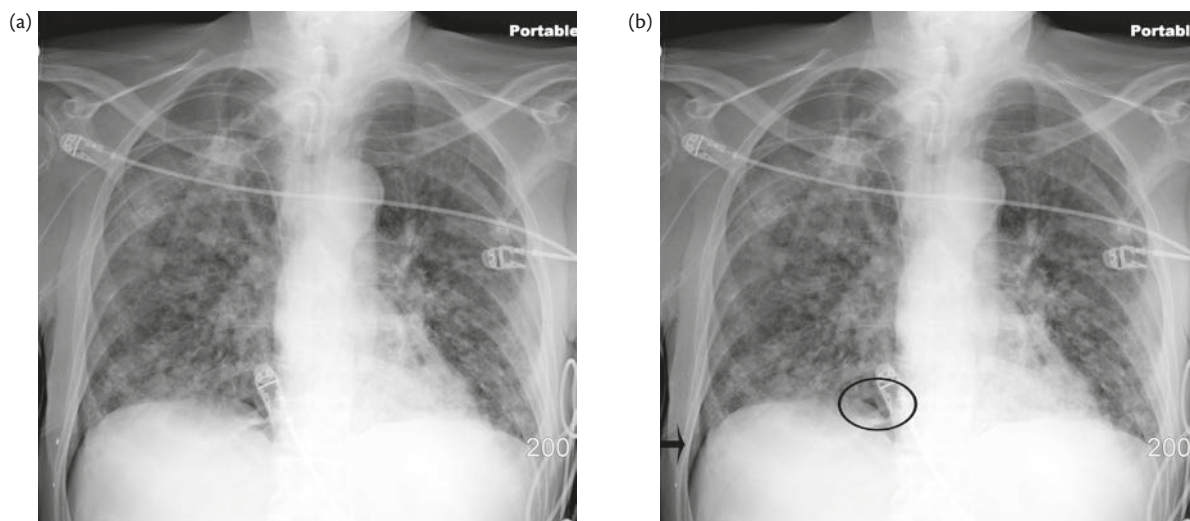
Case 8. (a) X-ray; (b) X-ray (circle shows small amount of air medially along the diaphragm).
